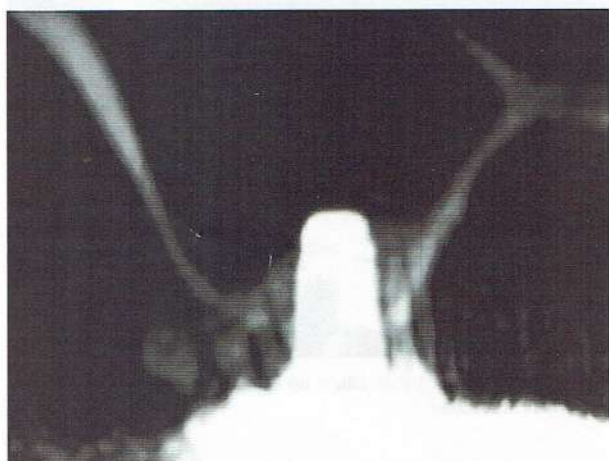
CT image of right first molar after 4-months loading showing new bone formation around implant
